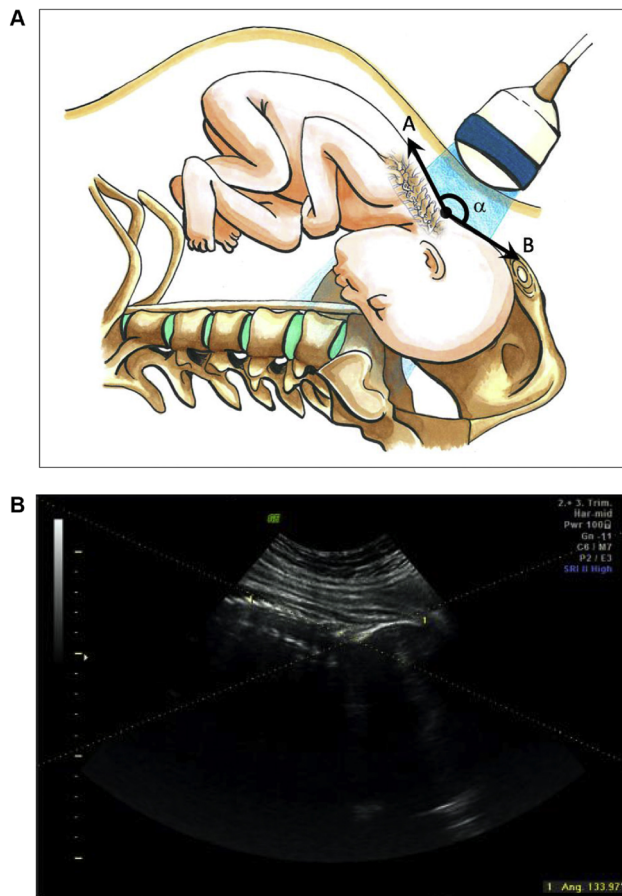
Transabdominal sonographic assessment of the degree of flexion of the fetal head in fetuses in occiput anterior position using the occiput-spine angle (Reproduced from reference [8]).
